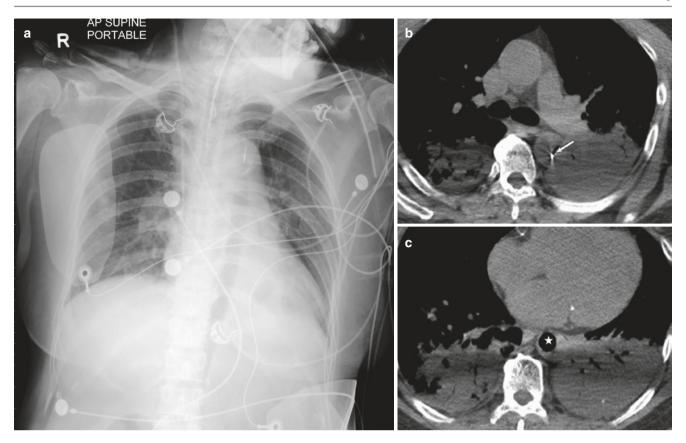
(a) Chest radiograph with inflated intra-aortic balloon pump catheter visualised as a tubular lucency along the course of the descending thoracic aorta. (b, c) Axial unenhanced CT images show the tip of catheter (arrow) and inflated catheter (asterisk) in descending aorta
